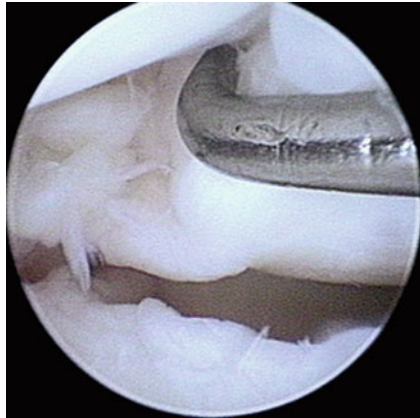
Case 2: The arthro CT-scan confirms a rupture of the scapholunate ligament. The associated arthroscopy showed a stage IV
